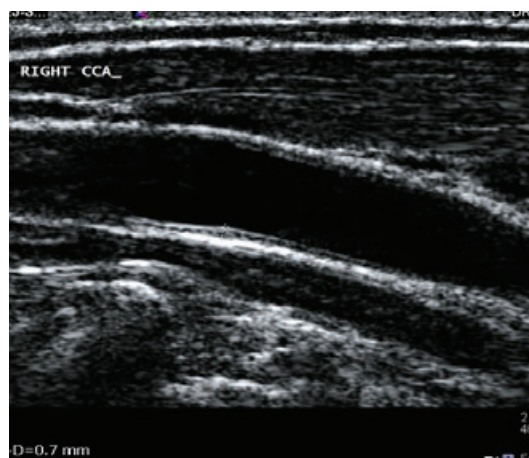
Longitudinal scan of the right CCA by B-mode ultrasonography.
